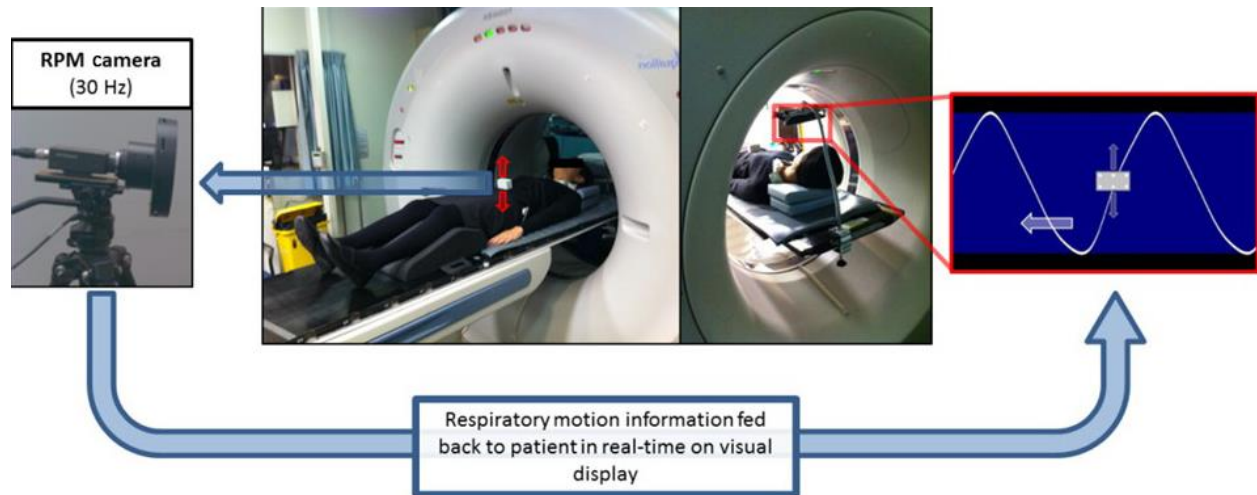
Study setup in CT sim room; biofeedback loop indicated with the RPM camera monitoring respiratory motion and displaying this respiratory motion to the patient in real time.
